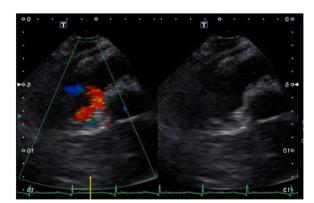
Transthoracic echocardiography with doppler study demonstrating, ectopic opening of the coronary artery and blood-stealing phenomenon at the pulmonary artery.
